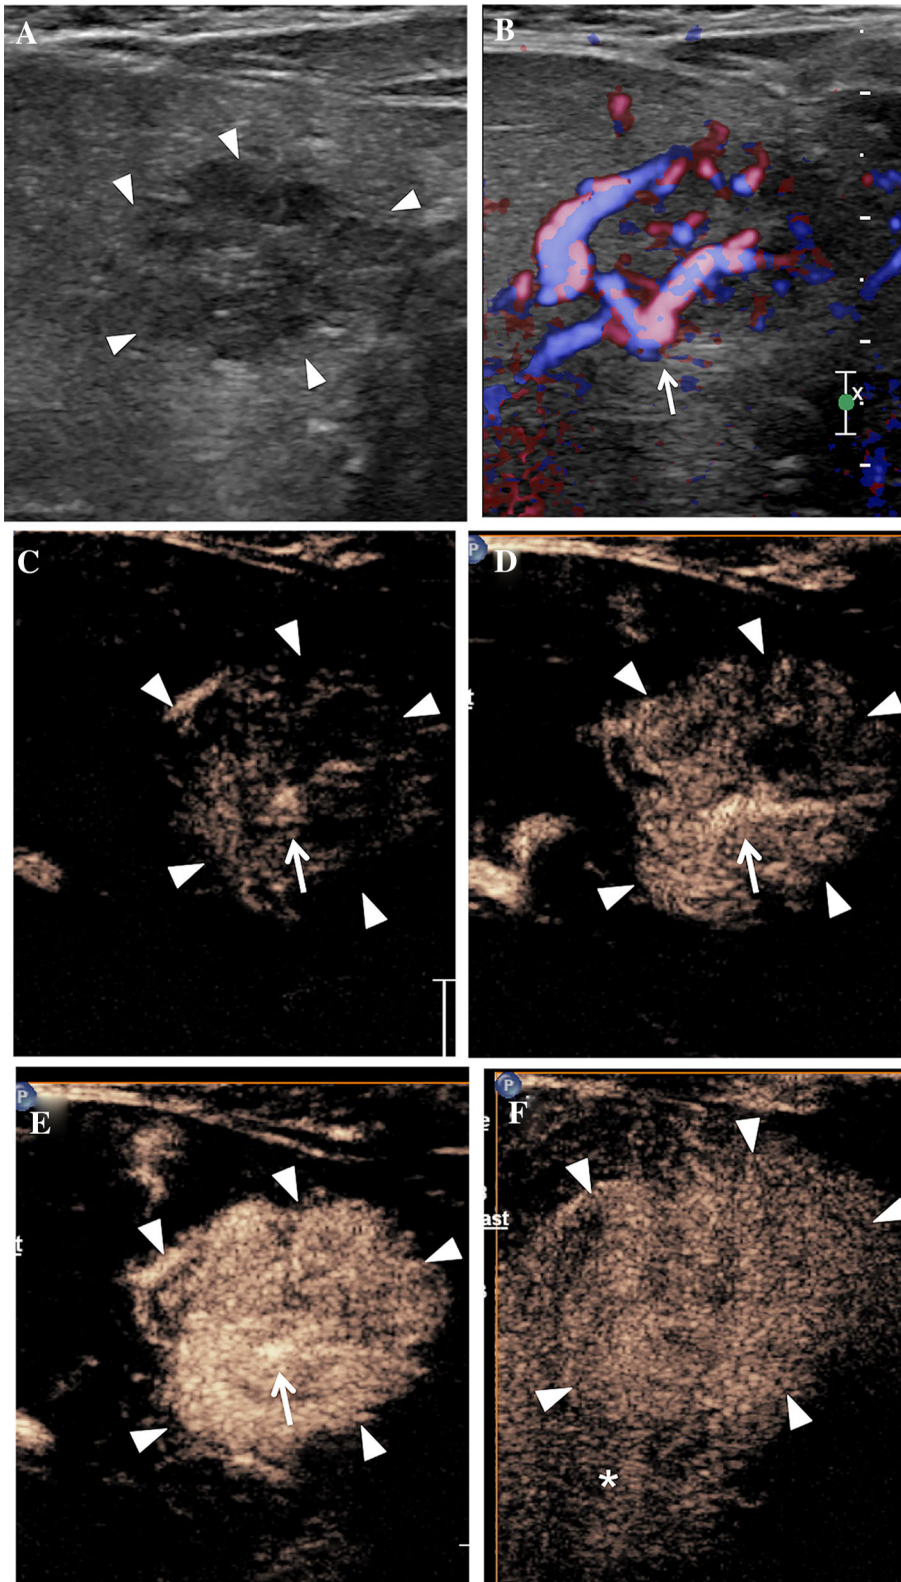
IV CEUS. Focal nodular hyperplasia. 9-month-old boy with Wolff-Hirschhorn syndrome. Incidentally detected focal liver lesion. A Baseline gray scale ultrasound. A predominantly hypoechoic and slightly heterogeneous liver lesion (arrowheads) is seen in the left hepatic lobe. B On color Doppler examination, the lesion demonstrates spoke-wheel pattern of vessels centrally (arrow). C--F Contrast-enhanced Ultrasound. The lesion (arrowheads) demonstrates early arterial enhancement with the presence of large feeding arterial branches centrally (arrow). In the portal-venous phase, the lesion becomes iso-enhancing compared with the adjacent liver parenchyma (asterisk). No unenhanced central scar is detected. These findings are consistent with focal nodular hyperplasia. No other investigation performed.
